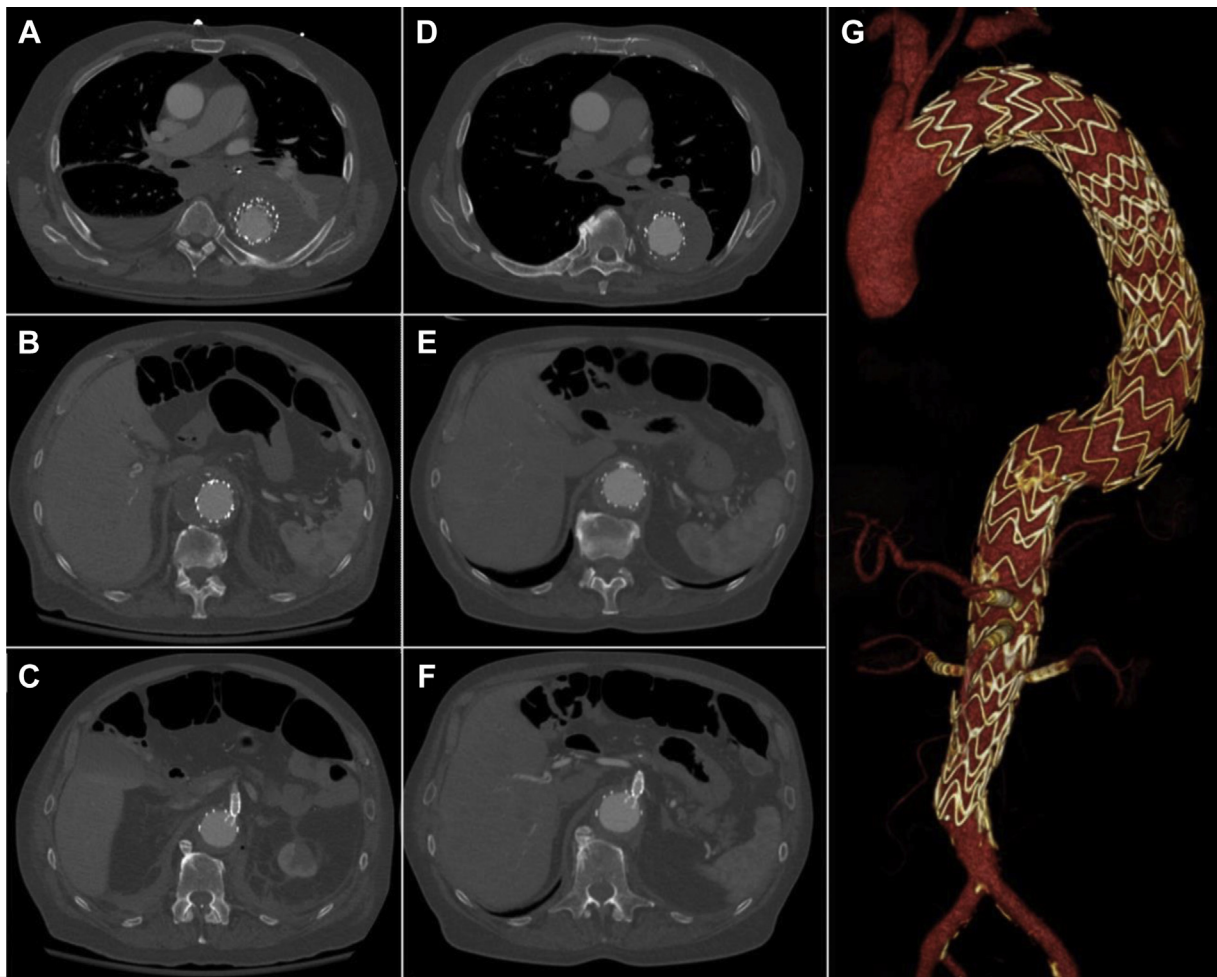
Postoperative computed tomography angiography (CTA) on day 5 (A-C) and at 3 months (D-G) show patent branch stents without stenosis, complete aneurysm exclusion without endoleak, and aneurysm sac regression.
